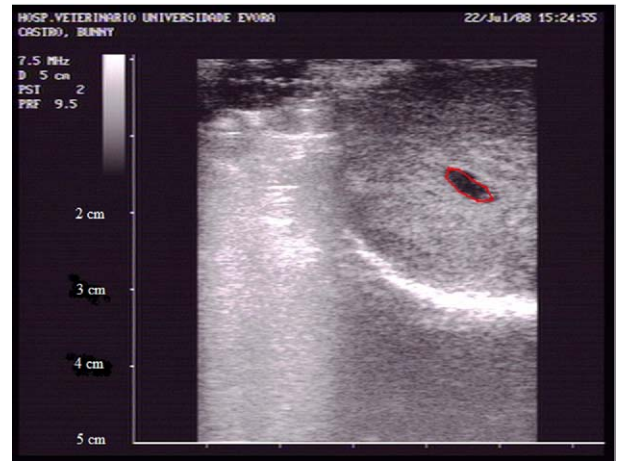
Ultrasonographic image of left testicle with cystic structure.
